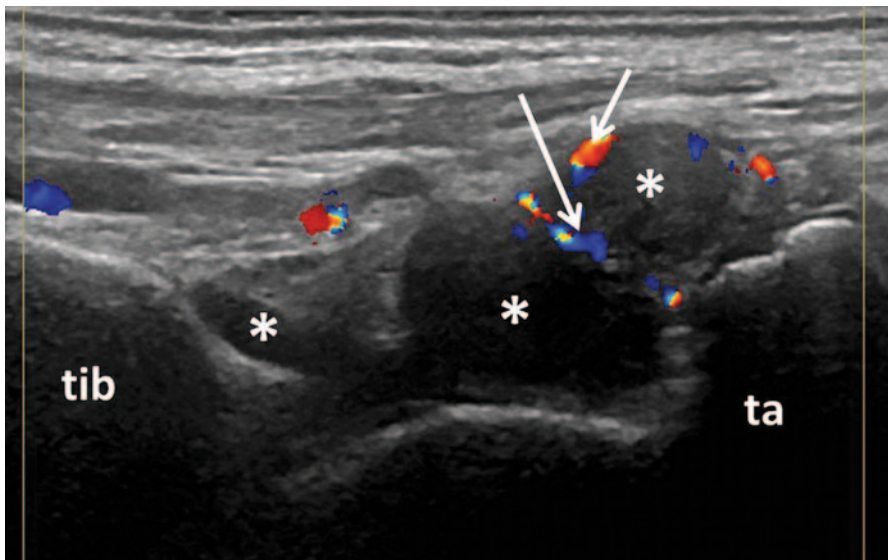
Longitudinal view of the dorsal aspect of the tibio-talar joint showing B-mode synovitis (*asterix*) with Doppler signal (*arrows*); *tib* tibia, *ta* talus
